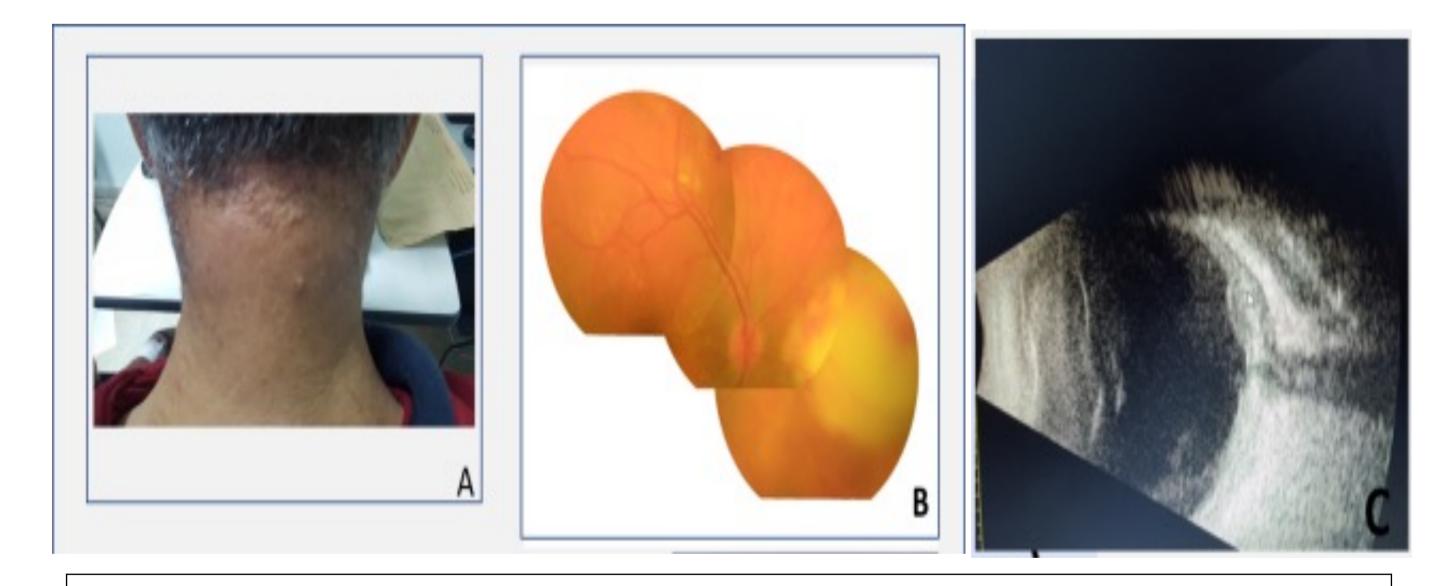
Bacterial endogenous endophthalmitis in a 52-years-old man with medical history of diabetes and staphylococcus neck abcess (A). Fundus photographs of the RE shows large necrotic retinal lesion nasal to the optic disc with surrounding retinal hemorrhages (B) . B-scan ultrasongraphy shows hyperechogene retinal lesion (arrow)(C).
